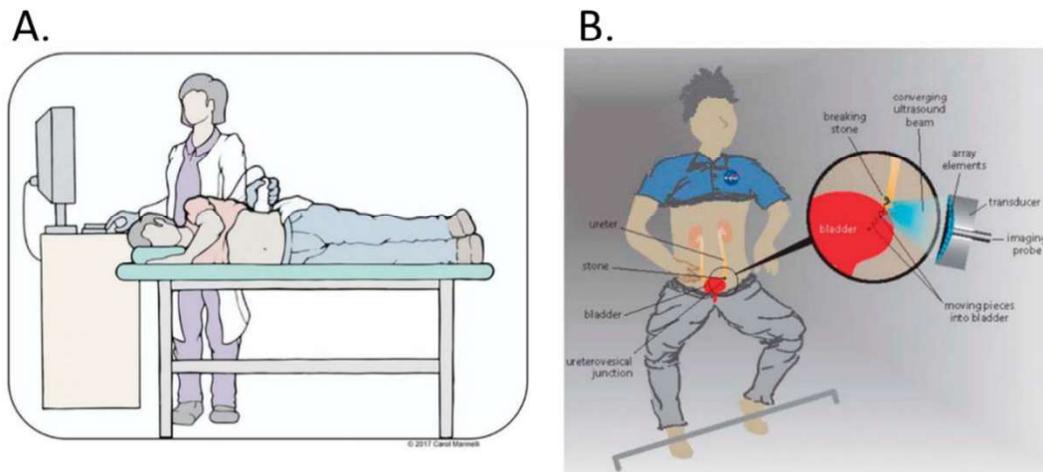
Figure modified from Hall et al. 2022 showing clinical positioning and use of ultrasonic stone propulsion and transcutaneous burst wave lithotripsy in A. terrestrial setting and B. spaceflight setting.*
